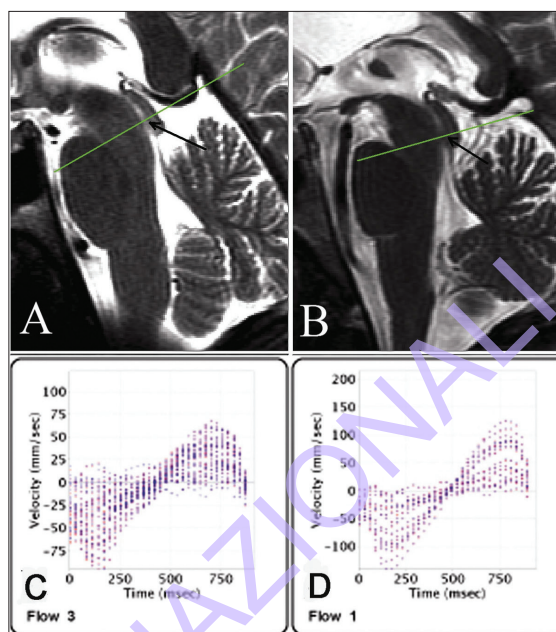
Cerebrospinal fluid flow measurement in the Sylvius aqueduct. Assessment in a HC (left) and MS patient (right), A-B. Sagittal T2 scans showing positioning for the MRI cine acquisition. Slices were perpendicular to the aqueduct (arrows), C-D. CSF velocity distribution within the aqueduct region of interest, for the 32 phases, calculated using the GE ReportCard software. Positive (or retrograde) flow is toward the 3<sup>rd</sup> ventricle and negative (or anterograde) flow toward the 4<sup>th</sup> ventricle. Normal CSF flow in the aqueduct is negative during systole and positive during diastole.
